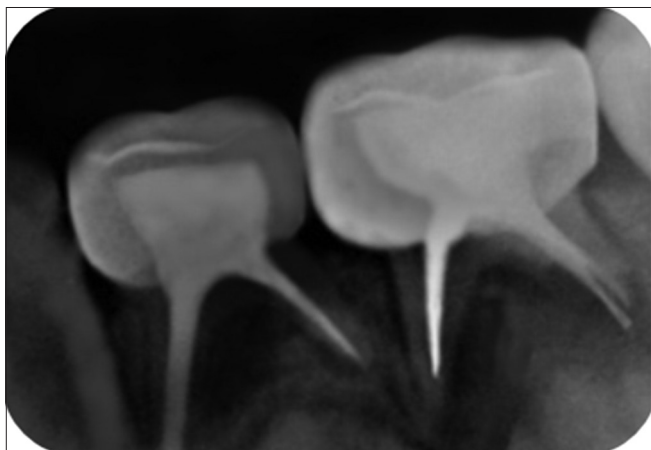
Periapical radiograph at the 1<sup>st</sup> follow-up (3 months)
